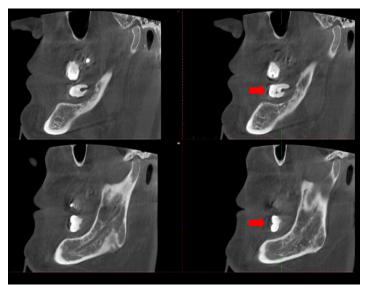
Extensive bone loss in the left mandible posterior area consistent with the floating tooth (red arrow) in CBCT.
